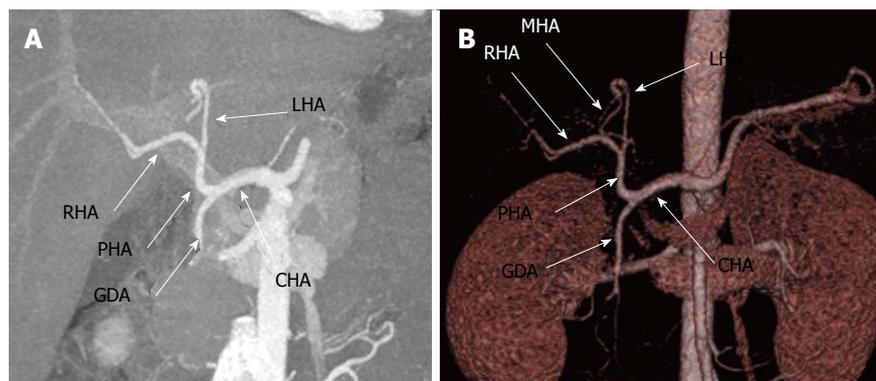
Conventional hepatic arterial anatomy depicted in (A) maximum intensity projection and (B) 3D volume-rendered images generated from a computed tomography angiogram. The CHA comes off the celiac axis, gives off the GDA to become the PHA which then bifurcates into the RHA and LHA. Note the MHA (the slender branch arising from left hepatic artery as seen in 1B) arising from LHA. CHA: Common hepatic artery; GDA: Gastroduodenal artery; PHA: Proper hepatic artery; RHA: Right hepatic artery; LHA: Left hepatic artery; MHA: Middle hepatic artery.
